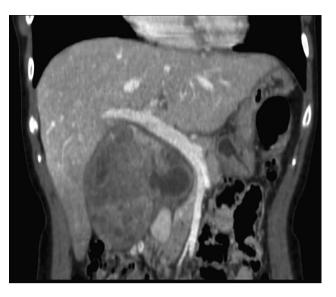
Pre-operative CT-scan demonstrating the presence of a retroperitoneal mass dislocating anteriorly the right kidney, laterally the pancreas and the duodenum and anteriorly the inferior vena cava.
